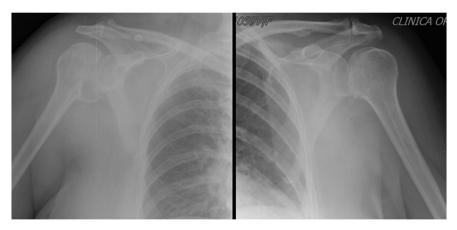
Emergency department X-ray in AP view.
